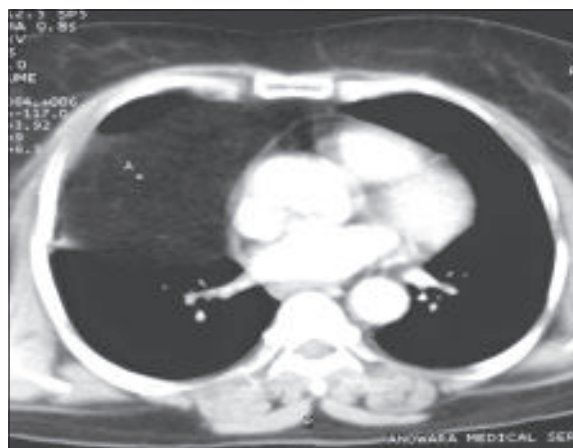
CT scan of the chest showing the mass occupying the right hemithorax near cardiophrenic angle.
